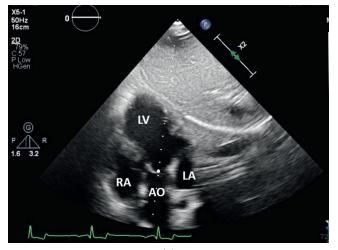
(a) Spectral Doppler of the aorta and outflow tract can be obtained from the apical 5 chamber view, lining the Doppler cursor up parallel to the left ventricular outflow tract and aorta. The gate (large dot) is placed proximal to the aortic valve for outflow tract velocity. (b) Aortic flow is recorded with PW or CW Doppler. With PW, the gate is placed in the aorta just distal to the aortic valve. The spectral display to the right shows downward flow below the baseline as blood exits the left ventricle. (*Continued*)
